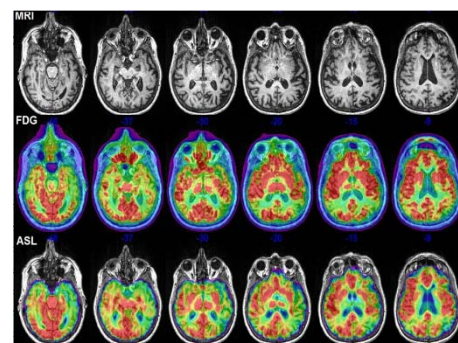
Representative MRI, FDG-PET, and ASL images from one patient.
